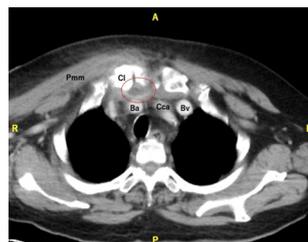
On admission, CT showed an abscess localised to the sternoclavicular joint (circle). a, anterior; Ba, brachiocephalic artery; Bv, brachiocephalic vein; CCa, common carotid artery; Cl, clavicle; L, left; Pmm, pectoralis major muscle; P, posterior; R, right.
